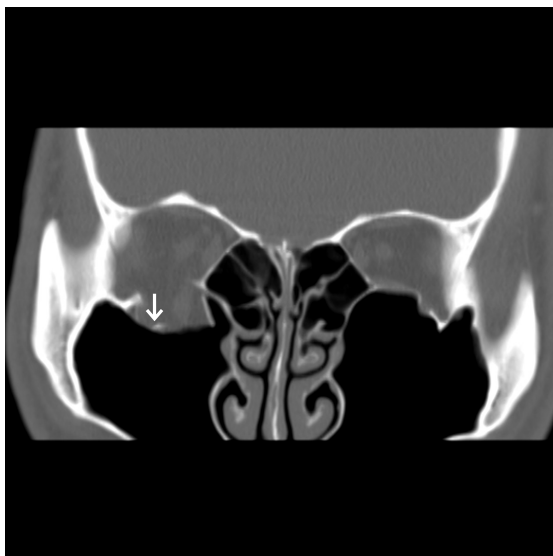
Coronal CT in bone window shows fracture of the right orbital floor (→).
